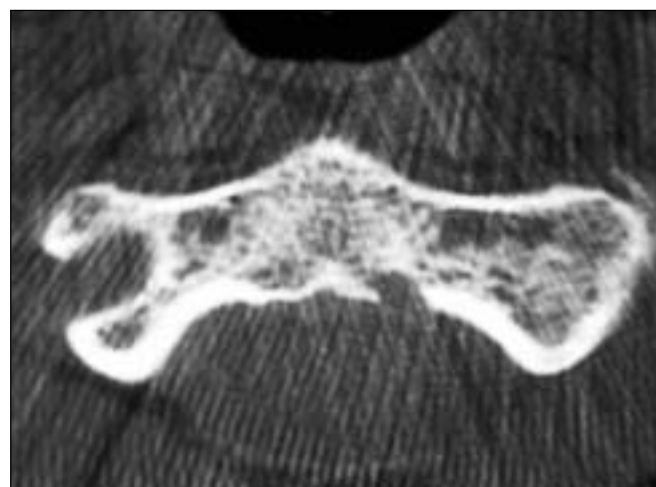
Axial CT scan of C2 revealing aberrant vertebral artery in the intended path of a right C1-2 transarticular screw
